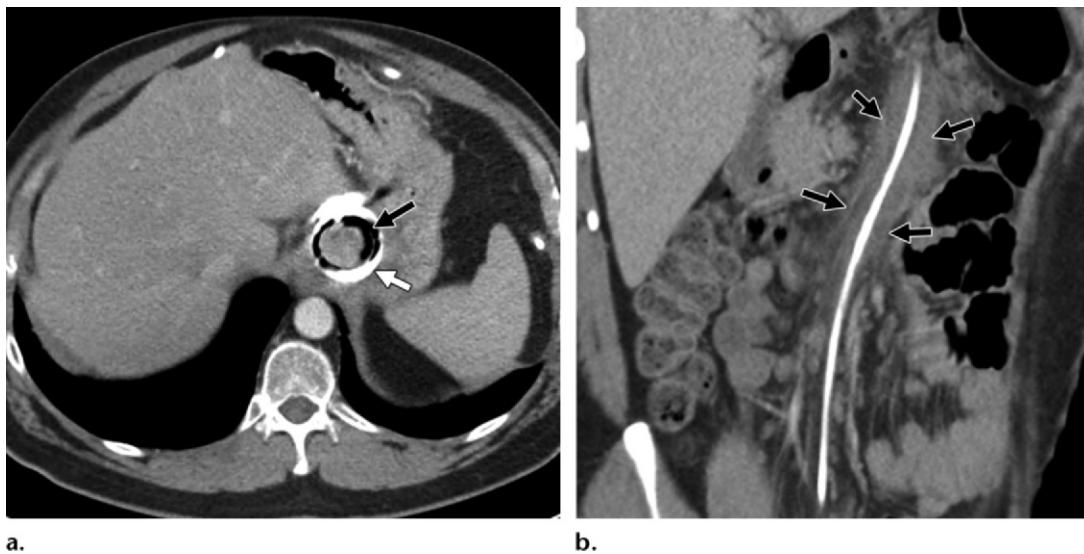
Transmurular erosion of a gastric band in a patient with abdominal pain. (a) Axial CT image demonstrates transmurular erosion of the gastric band (white arrow), which is delineated by gas (black arrow), indicating perforation. (b) Coronal CT image shows inflammatory fat stranding (arrows) along the entire course of the tubing tract.
